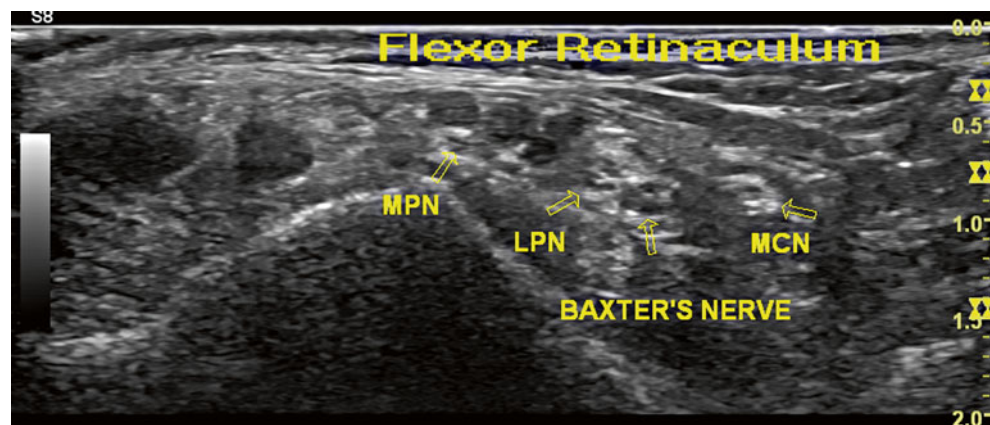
Ultrasound localization of the medial plantar nerve. (a) Initial US probe placement; (b) US image showing the vein-artery-vein configuration of the posterior tibial artery and veins; (c) rotated probe position; (d) ultrasound image of the probe at position (c); *MPN* medial
